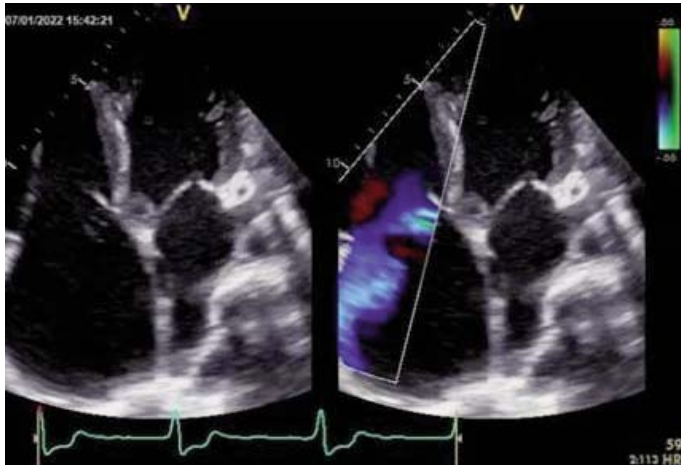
Apical four chambers view of transthoracic echocardiogram showing ruptured sinus of Valsalva aneurysm.
